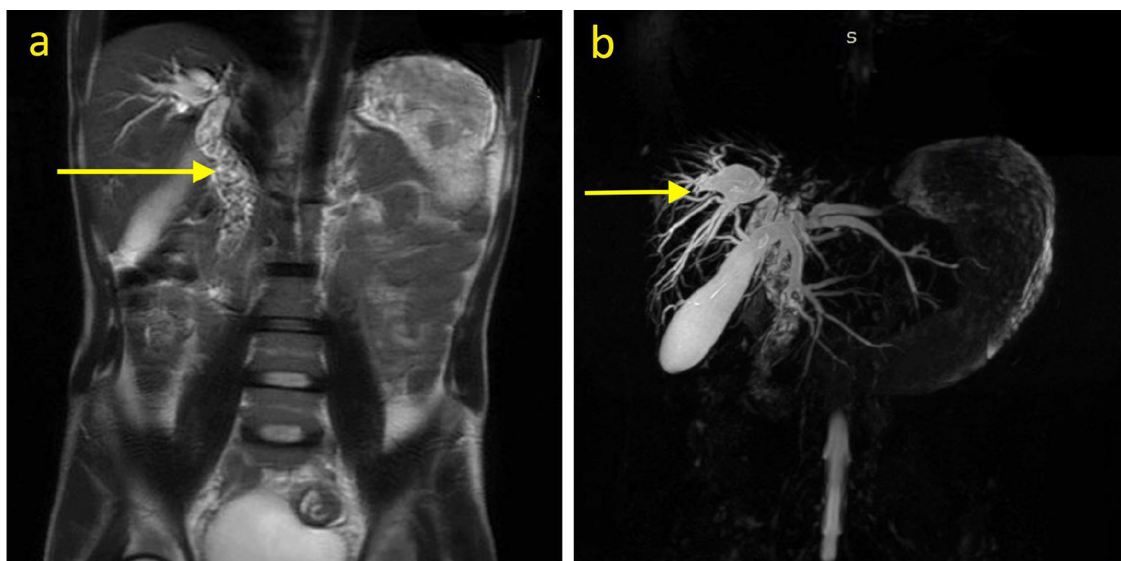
MRI (a) demonstrating extensively dilated common bile duct filled with hydatid cyst material seen as hypointense lesions (indicated by the yellow arrow), and MRCP (b) demonstrating dilated intrahepatic bile ducts (indicated by the yellow arrow).
